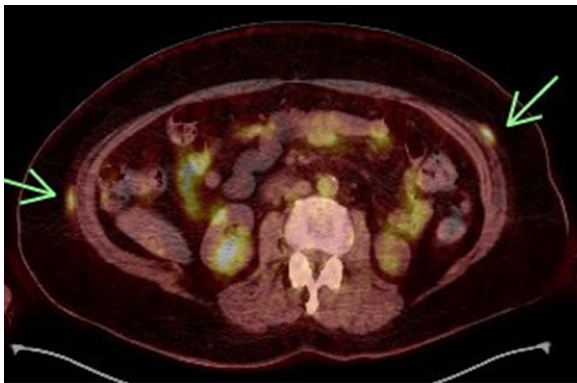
PET-CT shows increased metabolic activity in subcutaneous nodules in the abdominal wall (arrows). Multiple similar nodules were identified in the subcutaneous tissues of the chest, abdomen, and pelvis.
